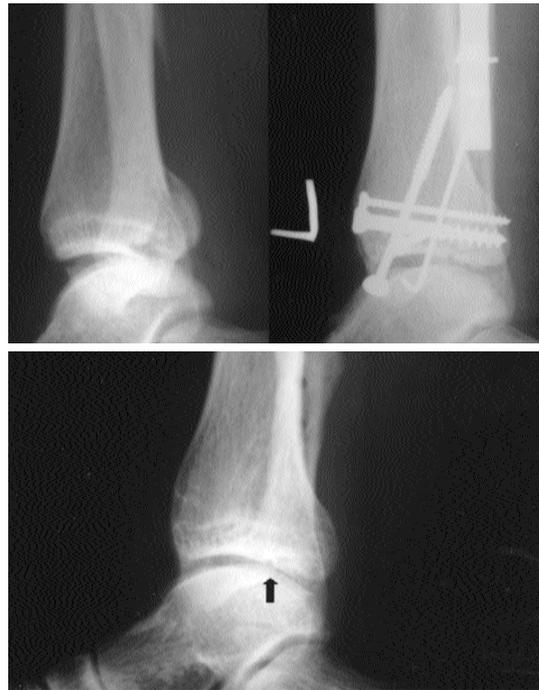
(A) Initial and immediate post-operative lateral plain radiographs. Two millimeter fracture gap was found without step off and size of the posterior malleolar fragment was 22% of the joint surface. Clinical result was not so good because of joint pain. (B) Follow up radiograph shows remnant gap on the articular surface(arrow).
